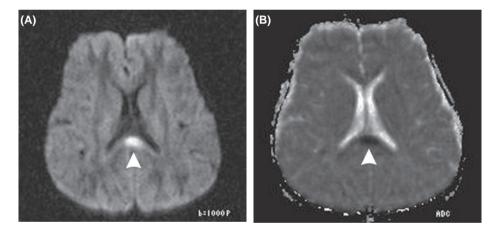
(A) Axial diffusion-weighted images (DWI, spin-echo planar imaging; TR=4521; b=1000) and (B) apparent diffusion coefficient (ADC) map. An ovoid lesion (arrow head) in the central splenium of the corpus callosum exhibited high intensity in DWI and reduced in ADC.
